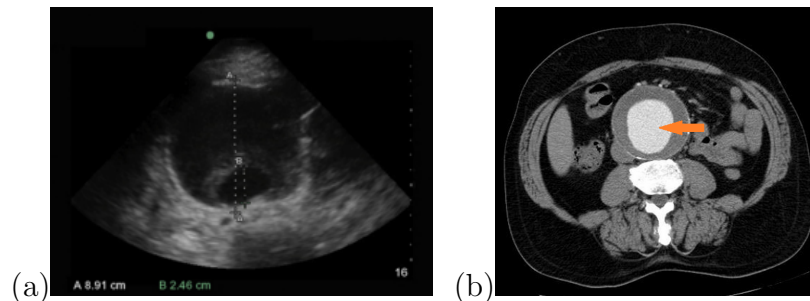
(a) Transverse ultrasound image demonstrating a wall-wall aorta diameter measurement and aortic lumen diameter [11]. (b) Computed tomography angiography showing the aortic lumen in light grey (arrow), surrounded by thrombus located in the aneurysm.
